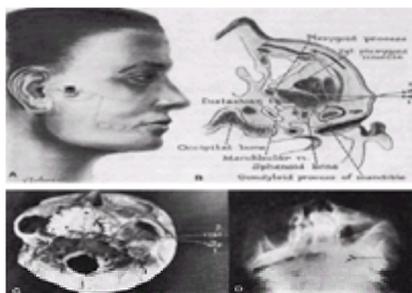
Mandibular nerve block by the lateral extraoral route. A: A skin wheal is raised just below the midpoint of the zygomatic arch, and an 8-cm, 22-gauge needle threaded with a rubber marker is inserted through it perpendicular to the skin. B: The needle is advanced until its point strikes the lateral pterygoid plate at a depth of about 4 cm from the skin (1). The marker is set 5 mm from the skin surface, and the needle is withdrawn until its point is subcutaneous and reinserted so that its point is 1 cm posterior to its previous position (2). The needle is gently advanced until the marker is flush with the skin, at which depth the bevel of the needle usually contacts the nerve just inferior to the foramen ovale and elicits paresthesia. For a diagnostic block, 2 to 3 mL of local anesthetic can be injected on the nerve but, for a neurolytic block, it is best to inject 1 mL of alcohol intraneurally. Because intraneural injection of alcohol is painful, it is essential to either give the patient a short-acting opioid, such as fentanyl, before injecting the alcohol or inject 0.5 mL of 2% lidocaine, wait about 30 minutes, and then inject the alcohol. C: Inferior part of the skull showing two needles in place. Needle 1 has its bevel against the lateral pterygoid plate, while needle 2 has its bevel in the center of the foramen ovale. D: Radiograph showing the needle (arrow) below the foramen ovale.
